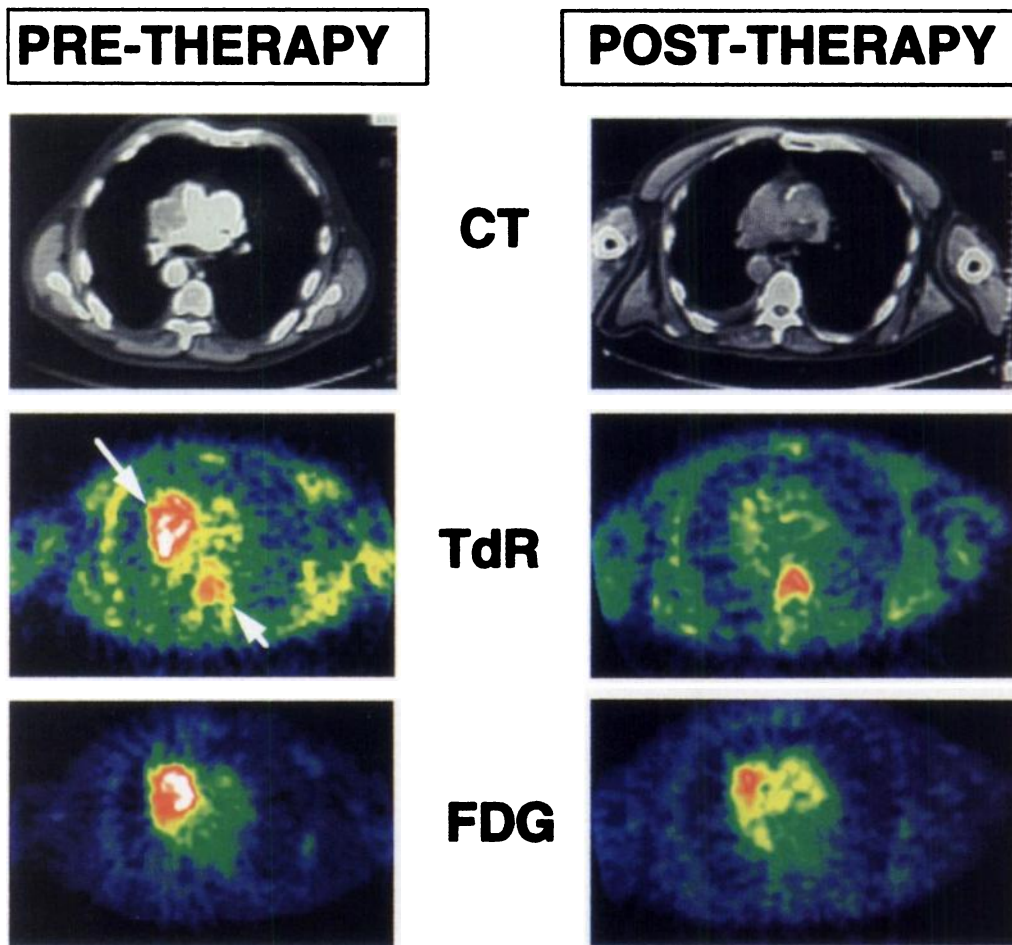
Images of small cell lung cancer (Patient 1). PET and CT images were obtained before and 6 days into therapy. Thymidine images were obtained 20–60 min postinjection, and FDG images obtained 30–60 min postinjection. Images of thymidine uptake show marked decline in tumor uptake (long arrow). Note thymidine uptake in vertebral marrow is visible before and after therapy (short arrow). Pretreatment CT scan was obtained with contrast medium, whereas post-treatment scan was obtained without contrast.
